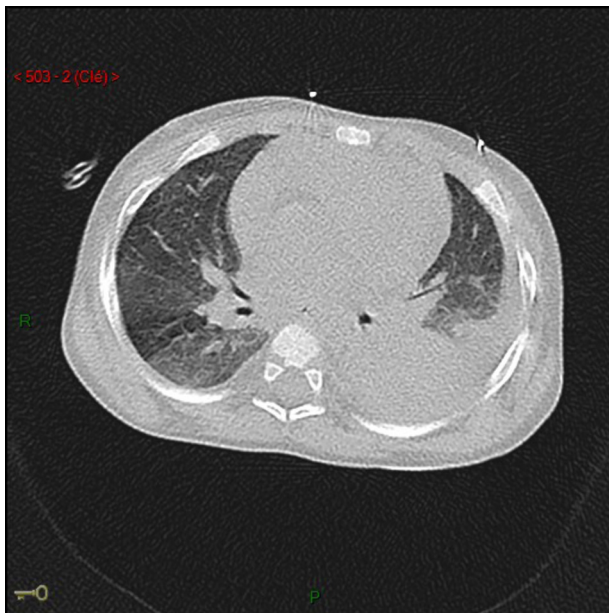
Axial non-enhanced chest computed tomography (CT). There is patchy ground-glass opacification of the right lower lobe and left pleural effusion and consolidation of the lower left lobe.
